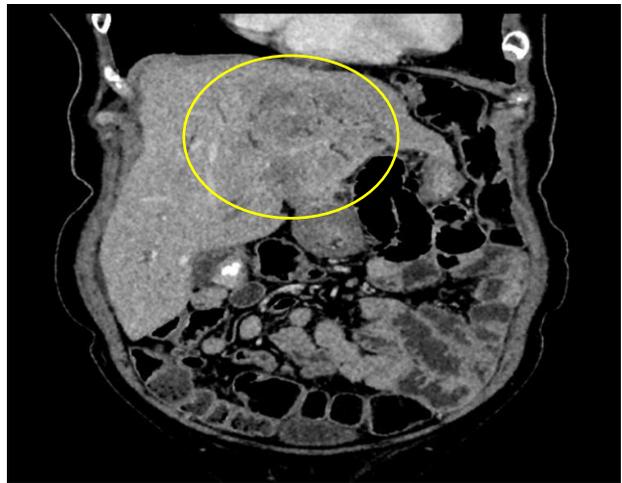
Coronal view contrast-enhanced computed tomography image demonstrating no arterial enhancing component within this mass (yellow circle). No gradual centripetal enhancement. This mass remained isodense to liver in delayed phase.
